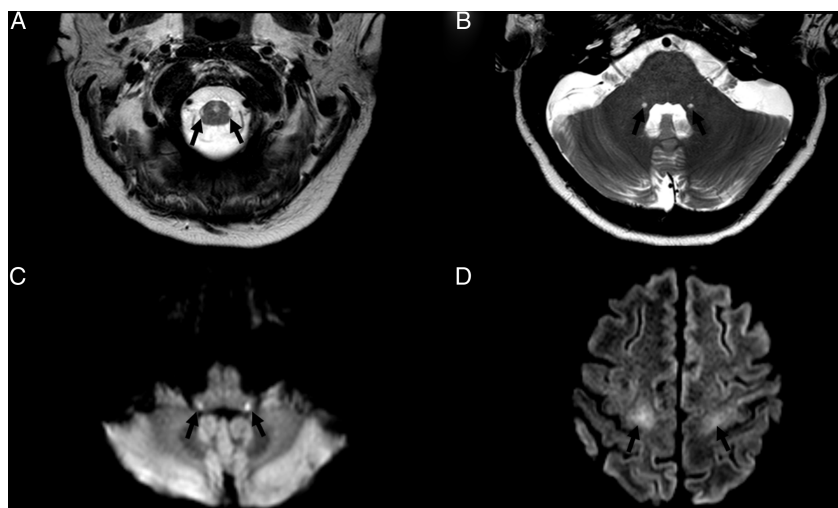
Axial T2-weighted image showing hyperintensities in the lateral columns, in the lateral corticospinal tract (A); symmetric hyperintensities in the inferior cerebellar peduncles (B). Axial diffusion shows hyperintensities (restricted diffusion) in the inferior cerebellar peduncles (C) and hyperintensities in the subcortical white matter of the precentral gyri (D).
